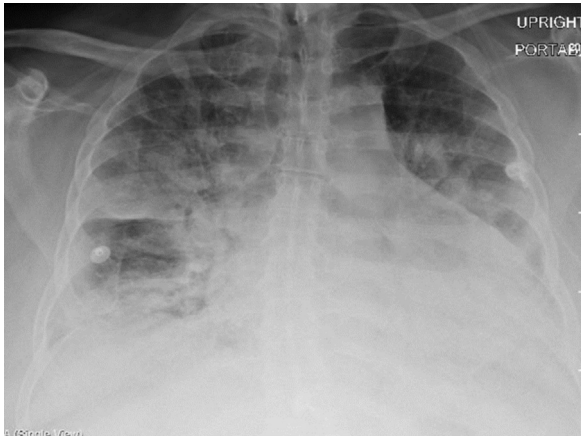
Chest radiograph on presentation: bilateral pulmonary opacities suggestive of multifocal pneumonia
